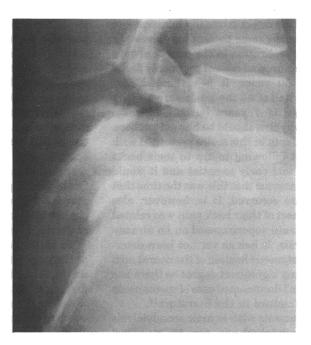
Preoperative radiographic appearance of isthmic spondylolysis of L5 in a 28-year-old man who had complained of increasing low back and right buttock pain over a 2-year-period
